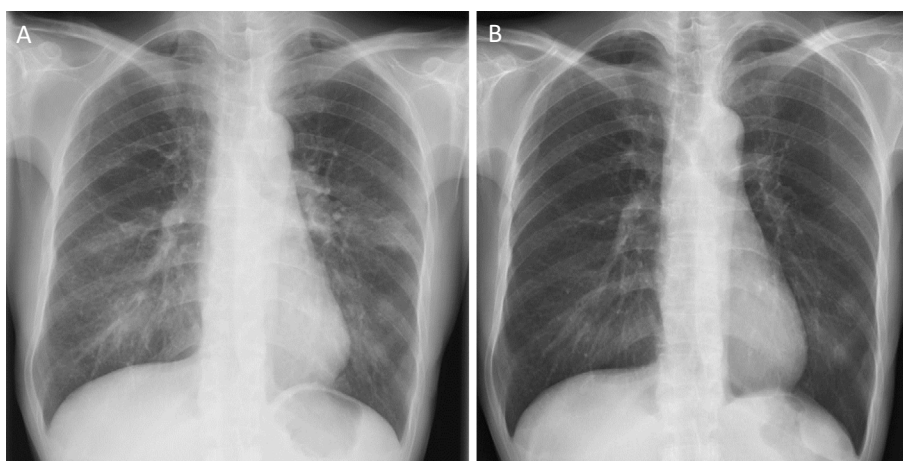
Chest X-ray on admission showed bilateral infiltrates (A). On day 12 after treatment with oral prednisolone, the bilateral infiltrates had improved (B).
